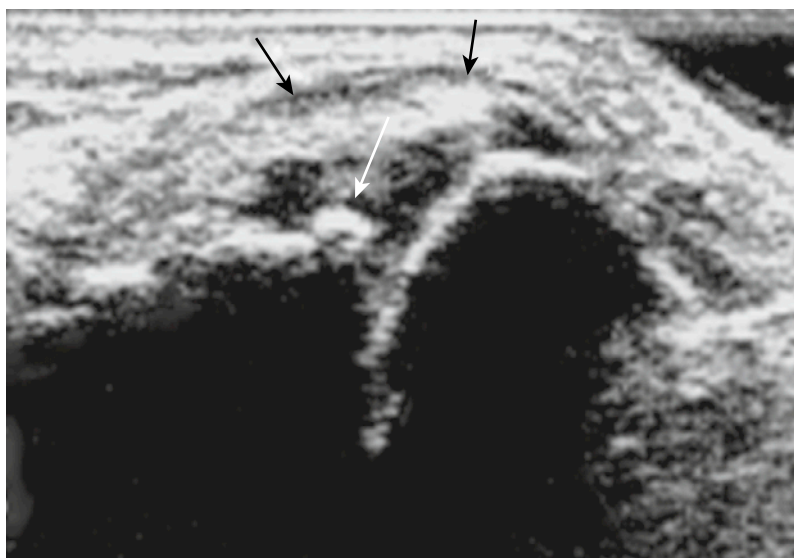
Ultrasound demonstrates an acromioclavicular joint with osteoarthritis. The 12-MHz longitudinal scan over the superior aspect of the joint shows an osteophyte (*white arrow*) and joint capsule thickening (*black arrows*).
